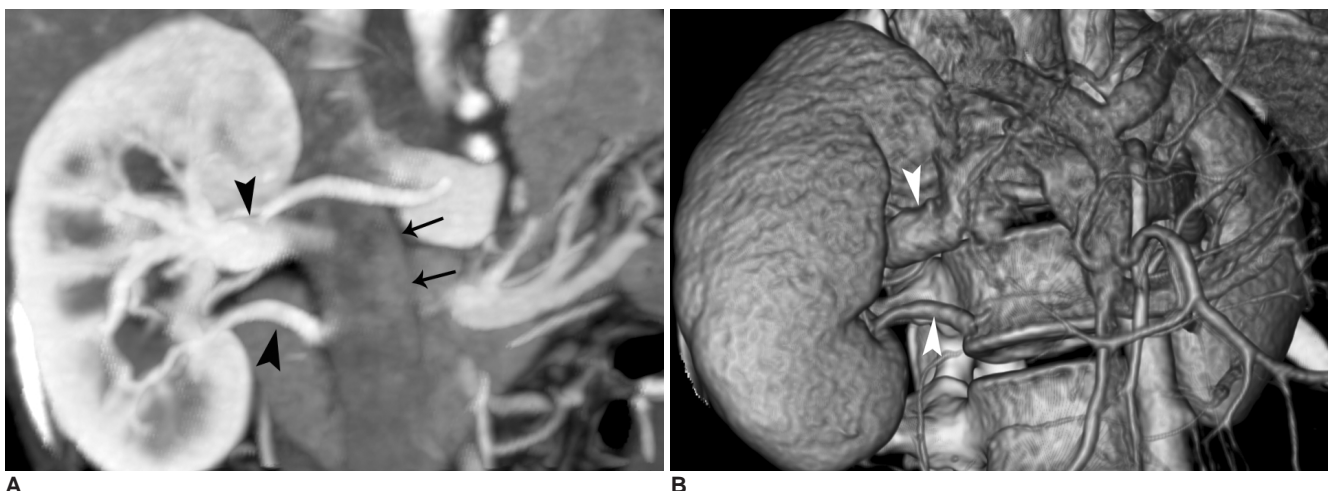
23-year-old female, right kidney donor. One right renal vein was detected at initial CT interpretation, but two right renal veins were found during donor nephrectomy.
